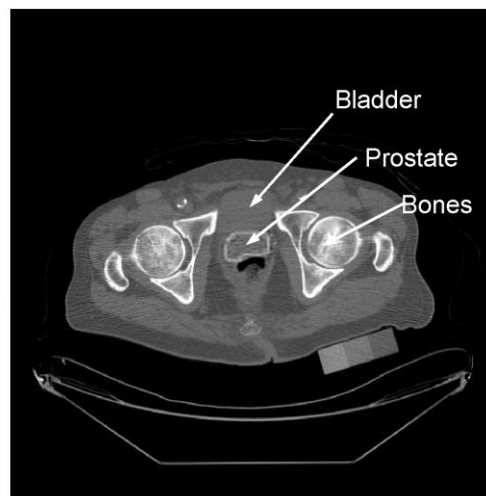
A manually segmented prostate (shown as the white contour) from a single slice of a pelvic CT scan.
